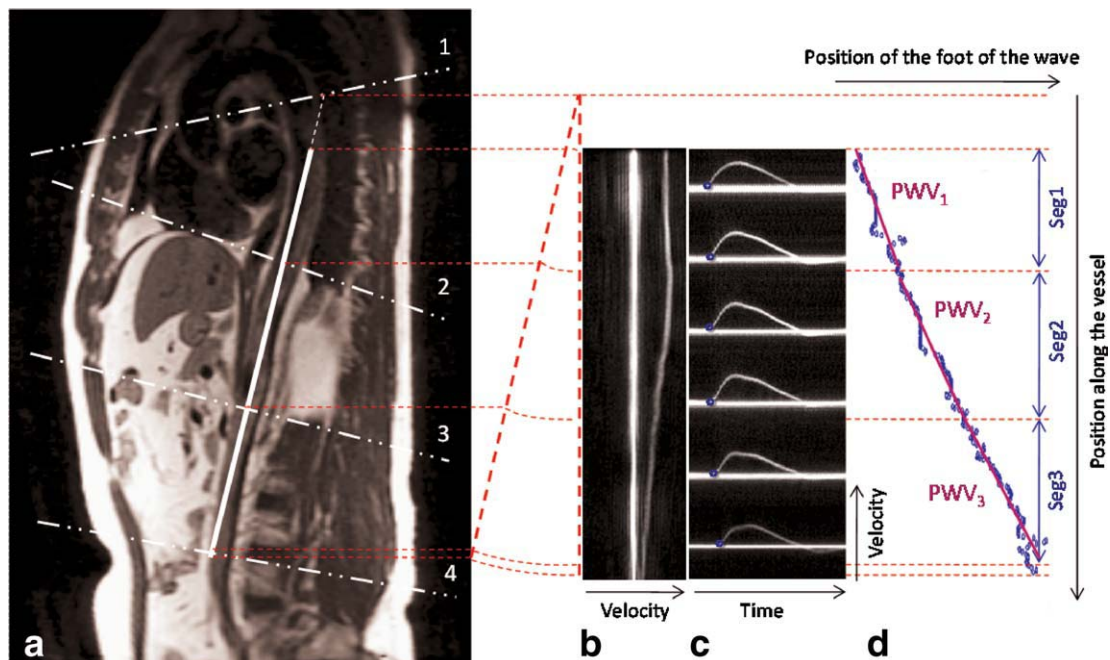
a: Localization of the aorta and prescription of the Fourier velocity encoded (FVE) M-mode pulse sequence (solid line); b: FVE M-mode image for an early cardiac phase showing the velocity distribution as a function of position along the pencil; c: FVE M-mode images reformatted to yield Doppler-like time-velocity traces; d: global and regional pulse wave velocities computed by best fit of the data representing position of the foot of the wave versus position along the vessel for the entire length of the pencil and for the three segments defined by the four planes in (a), respectively.
